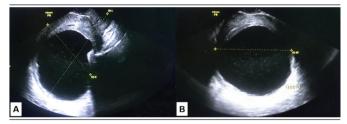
Abdominal ultrasonography of a 43-year-old female with atypical and cystic retroperitoneal leiomyoma
